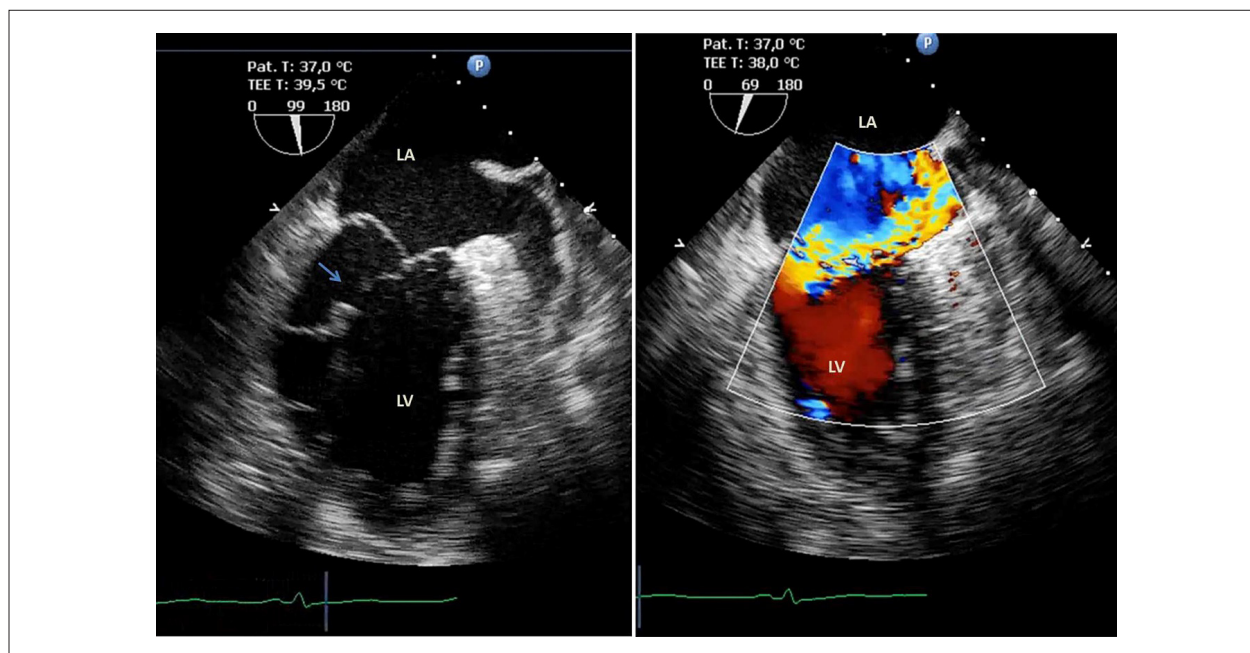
Transesophageal echocardiogram two-chamber view showing a 9 mm disruption of the posteromedial papillary muscle (pointed with an arrow) consistent with a contained, but morphologically imminent rupture, leading to a broad posterior leaflet prolapse and a severe mitral regurgitation with an eccentric jet. LA: Left Atria; LV: Left Ventricle.
